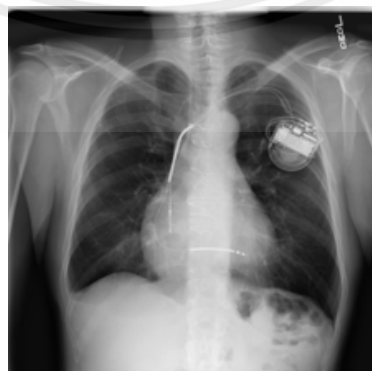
Example of Cardiomegaly chest X-Ray image (Wang, Yifan Peng, Le Lu, Zhiyong Lu, & Ronald M. Summers, 2018)
